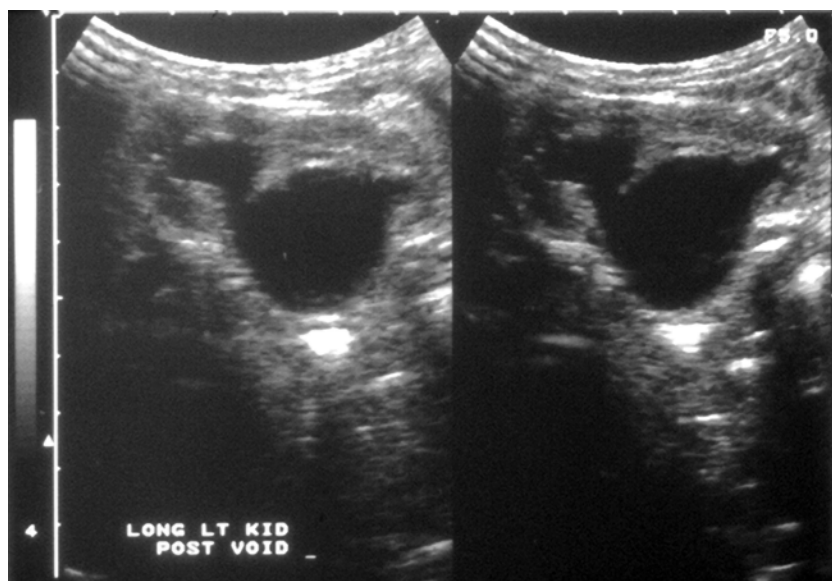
Ureteropelvic junction obstruction as seen on prenatal ultrasound. Note dilatation of renal pelvis.
